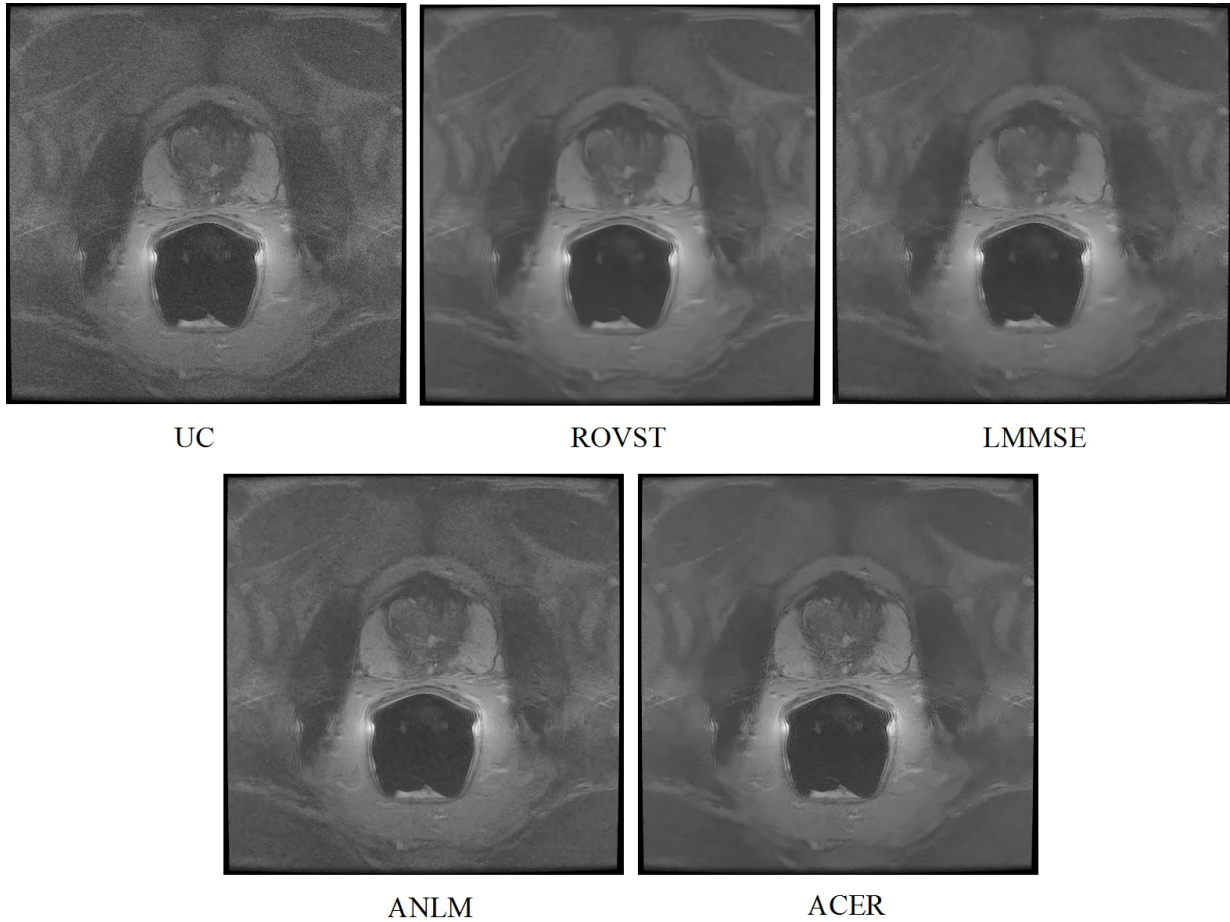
Case 3: A central T2 MRI slice from a patient imaged using a Medrad inflatable ERC compensated by various approaches. LMMSE and ROVST suppress noise in the background, consequently blurring details within the prostate. ACER effectively compensates the noise in low signal regions while taking advantage of the high signal near the coil. ANLM maintains similar detail preservation however retains some noise.
